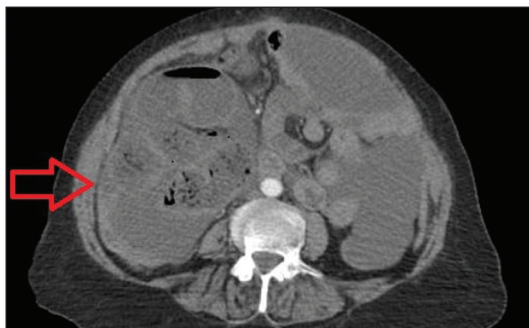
Conglomerated and dilated small bowel loops (preoperative computed tomography view).
